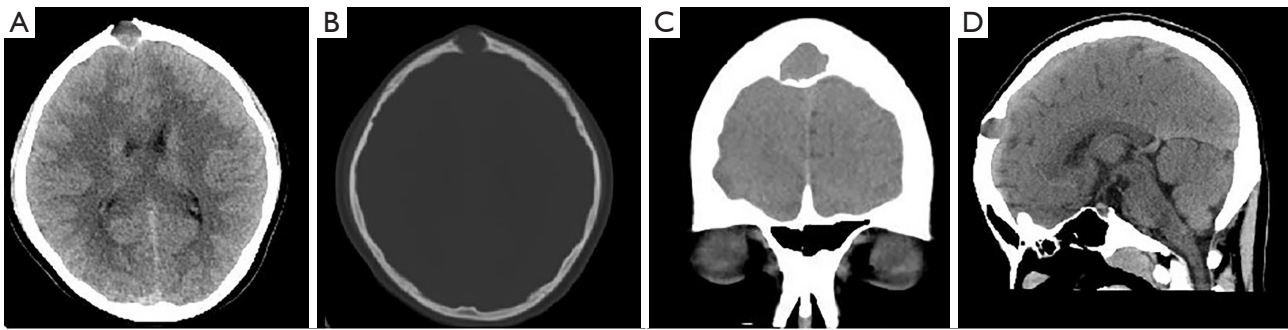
Preoperative cranial CT examination. Axial (A), sagittal (C), and coronal (D) head CT showed a 2.0 cm × 1.8 cm nodular mixed density shadow. The bone window (B) showed erosive and expansive bone destruction. CT, computed tomography.
